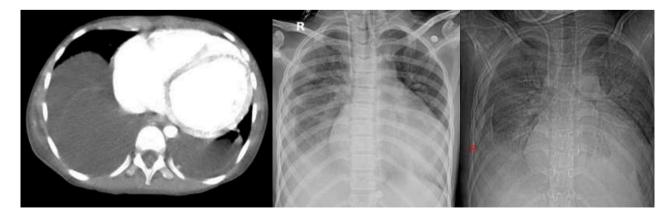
Chest X-ray showing dilated cardiac shadow and HRCT showing dilated thinned cardiac chambers
